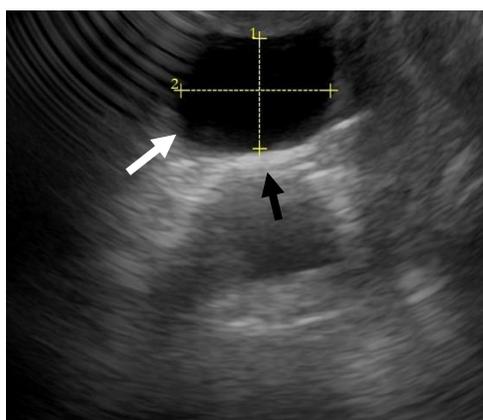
Ultrasonography image shows well-defined anechoic cystic lesion about 2 cm diameter (White arrow) with posterior acoustic enhancement (black arrow).
